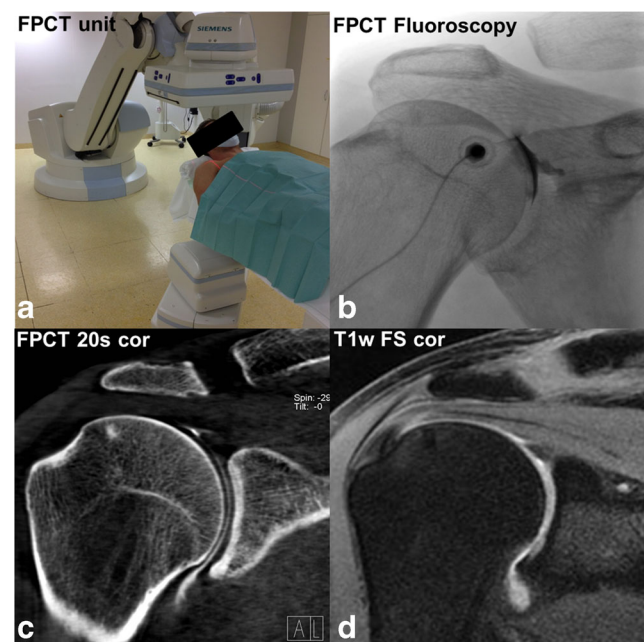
Twenty-nine-year-old male patient lying supine on the examination table of the roboter arm mounted C-arm flat panel CT (FPCT) unit with the right shoulder in the isocentre of the eccentric C-arm rotation trajectory (a). After fluoroscopically guided contrast injection (b) FPCT 20-s arthrography of the right shoulder was performed in the same unit (c, coronal reformat). Patient underwent MR arthrography of the same shoulder joint immediately after FPCT (d, T1-weighted fat saturated (FS) coronal image). Normal glenohumeral joint with intact supraspinatus tendon is visualized in both modalities
